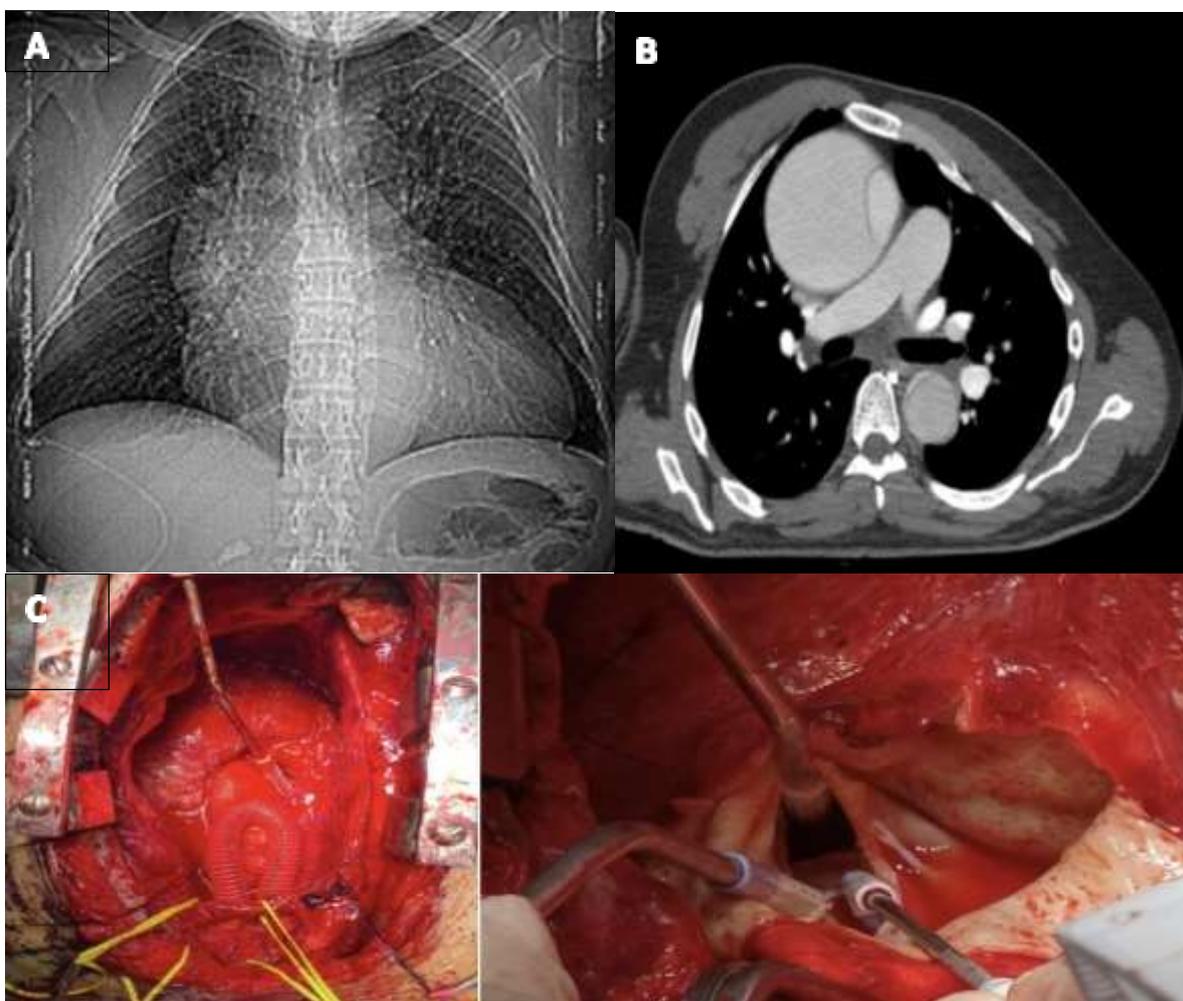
A) Chest x-ray with aortic aneurysm and cardiomegaly. B) Contrast-enhanced tomography with aneurysmal dissection in the aortic root. C) Bentall and Bono technique in truelumen and aortic dissection flap.
